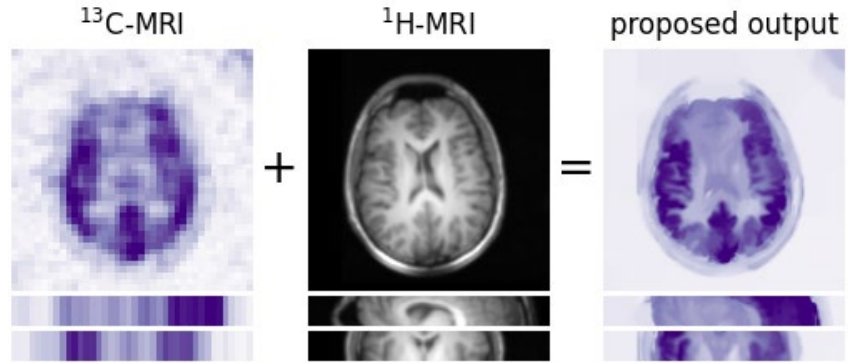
Data used in the proposed method: Instead of taking a single ^1H -MRI slice to upsample the ^{13}C -MRI data, we propose using a stack of slices covering the whole ^{13}C -MRI field-of-view
